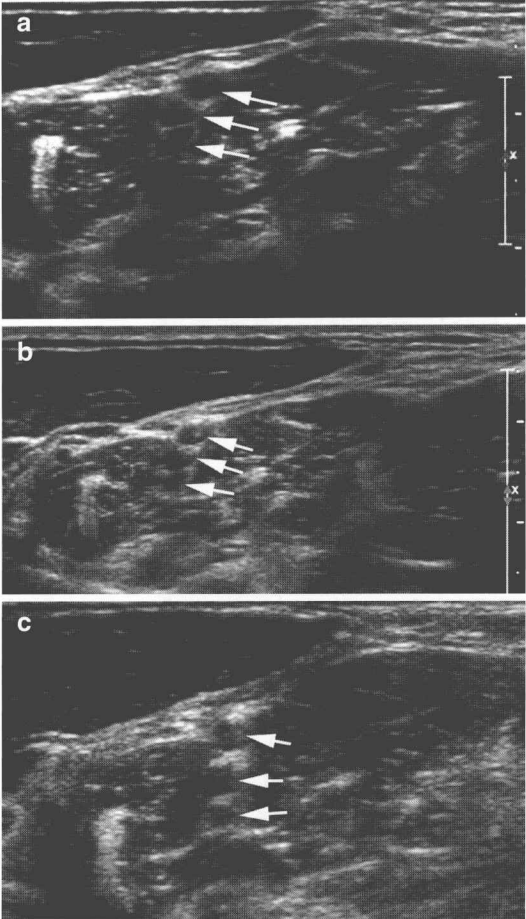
Transverse ultrasound images through the brachial plexus (*arrows* plexus trunks) in a normal volunteer taken with a 17 MHz (a), 12 MHz (b), and 9 MHz (c) transducer (all images taken on a Philips IU22 under the same preset). Note that for deep-lying structures covered by thick soft tissues a 12 MHz or even 9 MHz transducer results in most acceptable image quality
